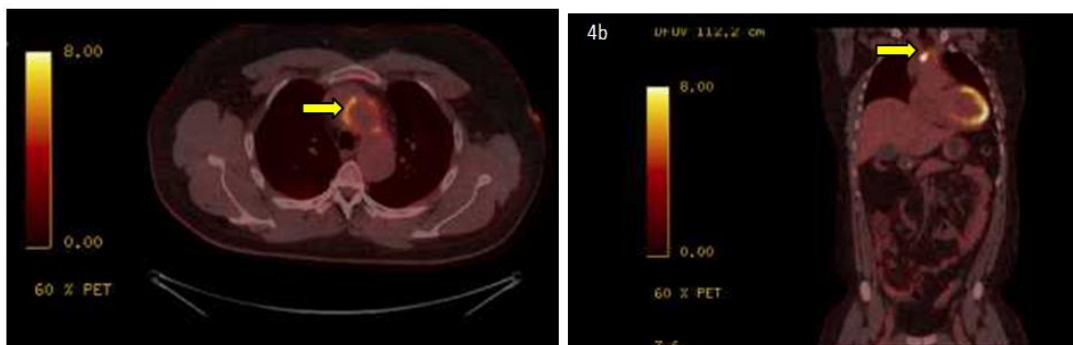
FDG PET scan axial showing intense accumulation of ^{18}F – FDG around the arch of aorta and left subclavian artery (solid arrow)
